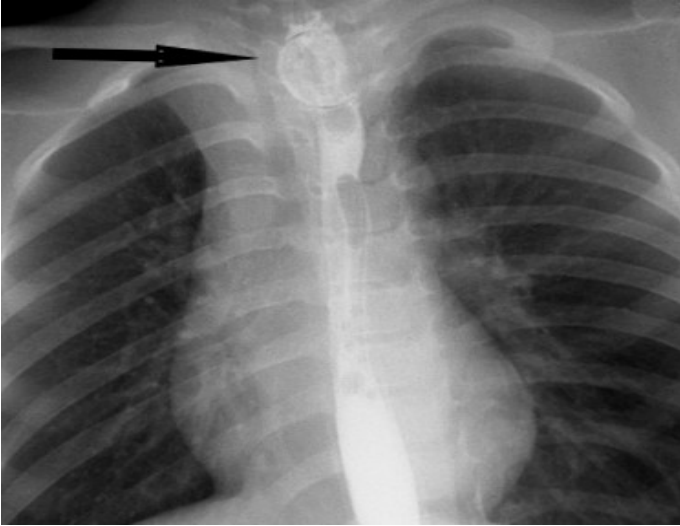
A radiolucent foreign body is visualized with a filling defect on the esophageal passage radiograph
